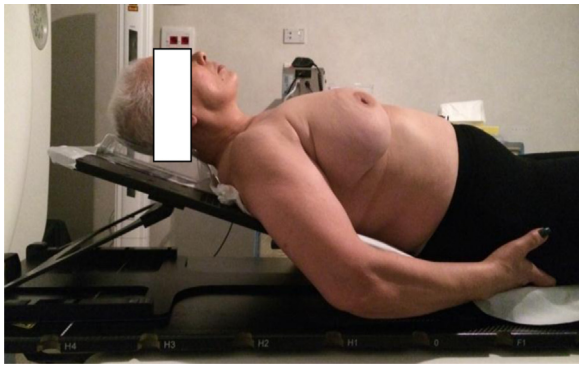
Example of a CT planning scan performed with the inclined board. (Color version of figure is available online.)
